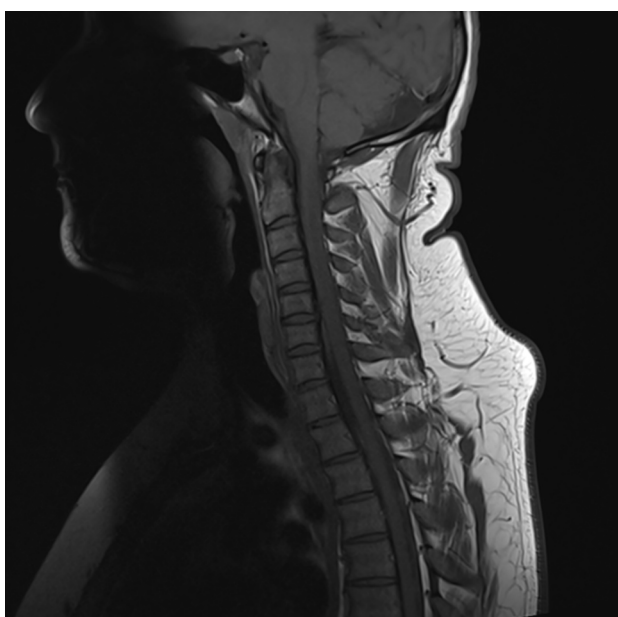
SSagittal T1-weighted image of the cervical spine showing no hyper or hypointense areas within the spinal cord
